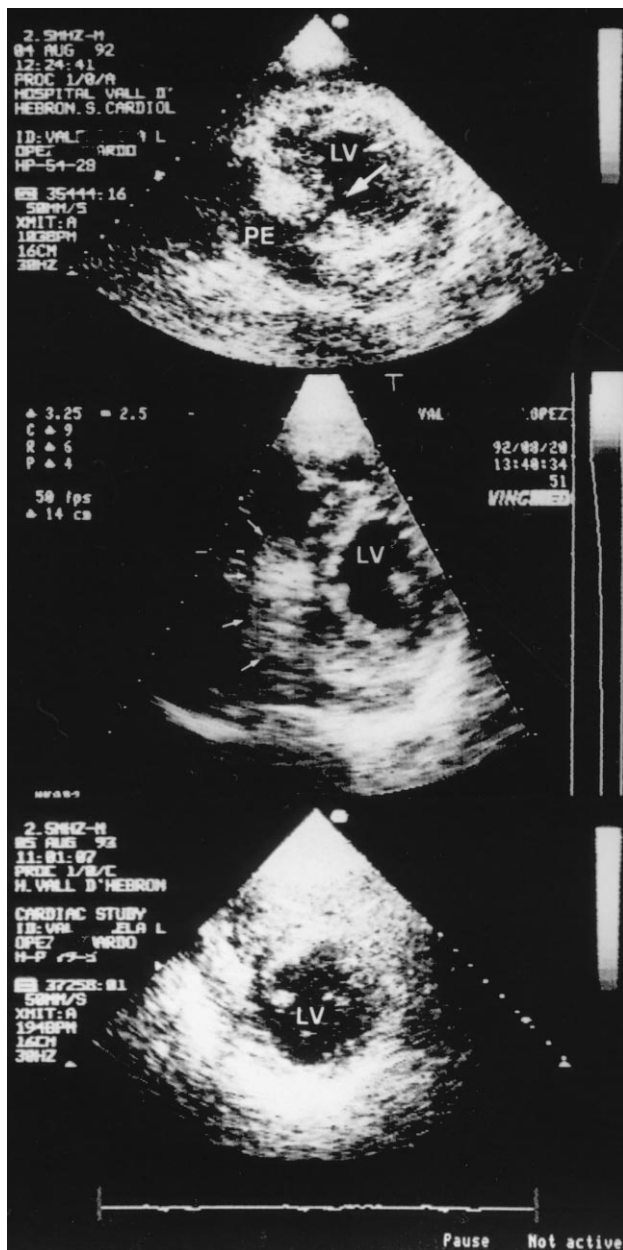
Sequential echocardiographic images of LVFWR in a 56-year old man (Patient 11) with a lateral myocardial infarction. Top, Shortly after clinical recognition of the LVFWR; arrow indicates the rupture site, and significant pericardial effusion (PE) can be seen. Middle, Sixteen days later, there is an extensive fibrinous cap attached to the ruptured site (arrows). Bottom, Twelve months later, the fibrin deposits and pericardial effusion are no longer apparent. LV = left ventricle.
